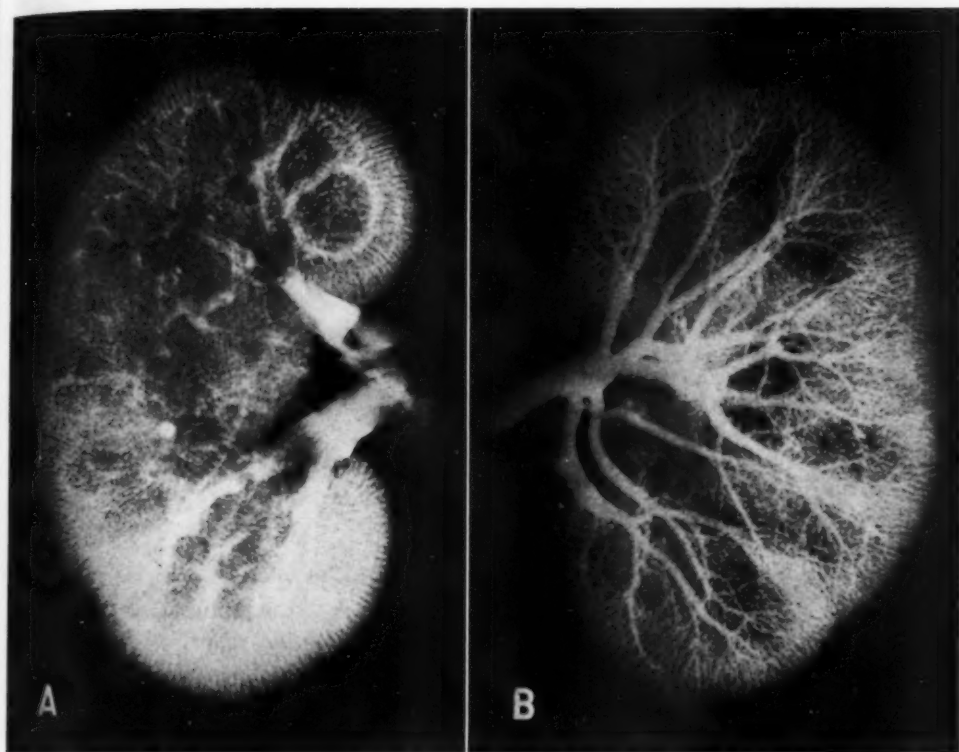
A. Right kidney of white male, age 37 years, with roentgen opaque mass injection of the renal veins. The larger vessels are not so completely filled as in the arterial injection of the opposite kidney (2B). Injections were made at two points. The vessels were of approximately the same degree of minuteness as found in the arterial tree.
